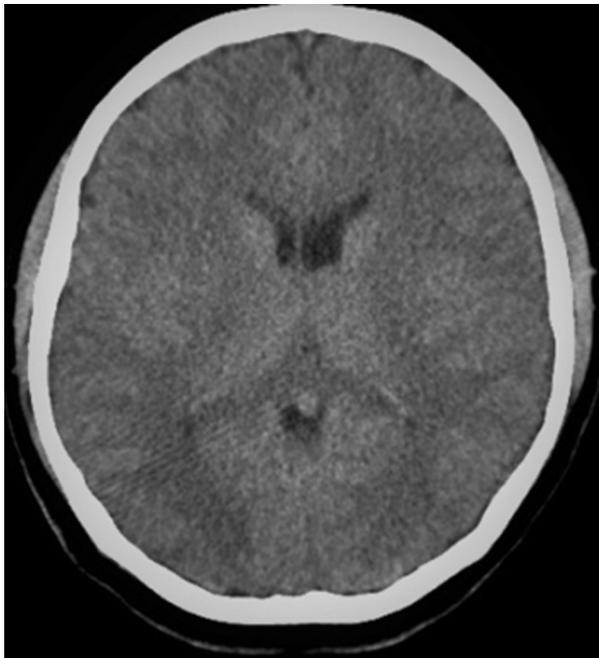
Cerebral CT (Postoperative first week)
